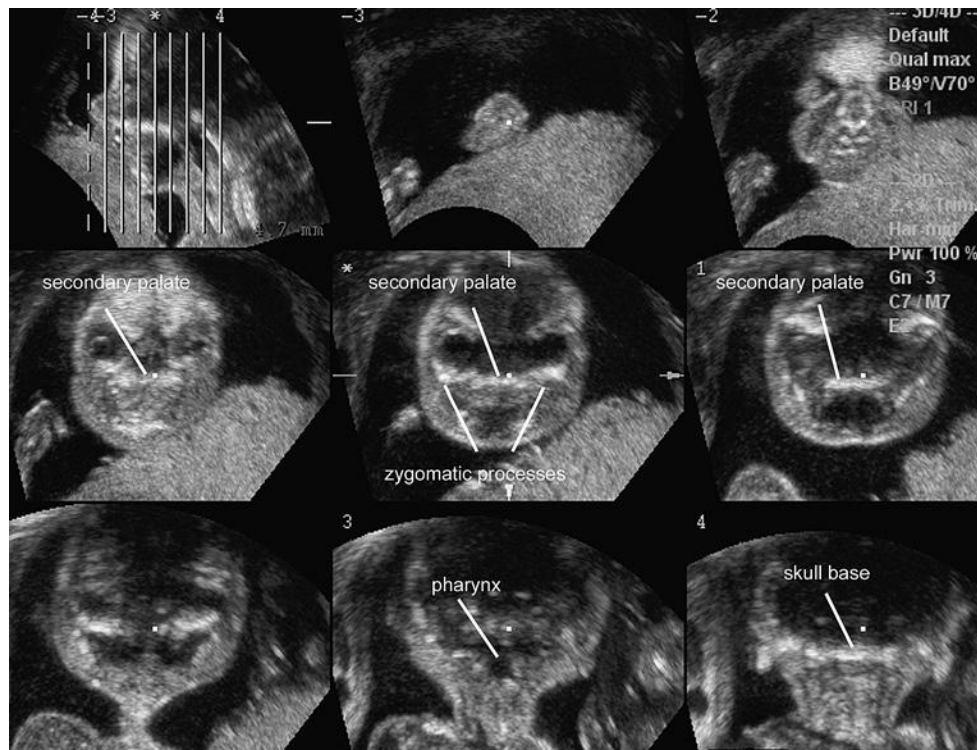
Three-dimensional ultrasound imaging: Tomographic ultrasound imaging (TUI) (multiple slices) of the fetal palate visualized with an angled approach. Comparing the reference midsagittal view with the coronal slices, the entire secondary palate is clearly demonstrated.
